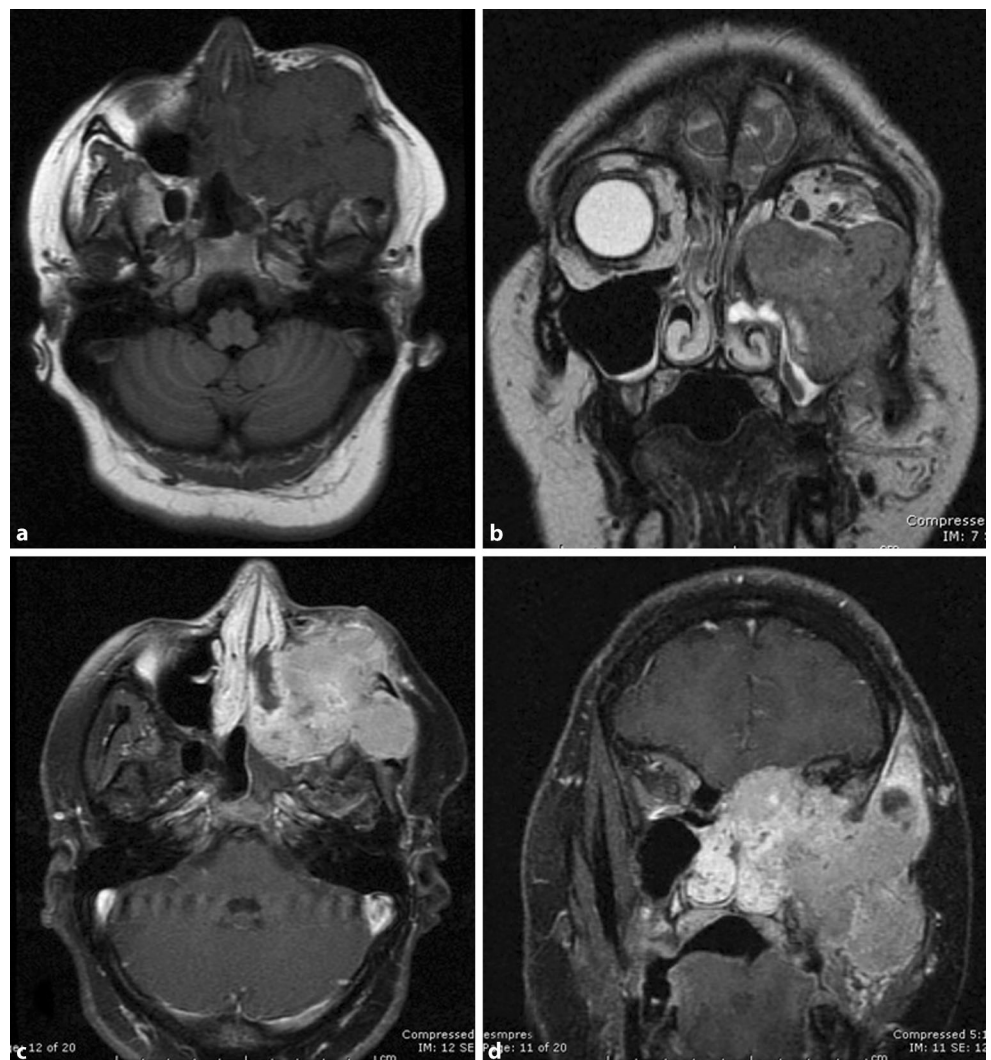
Magnetic resonance imaging (MRI). Large solid expansive left orbito-maxillofacial process with intracranial invasion and moderate enhancement following intravenous injection of paramagnetic contrast medium. a T1 axial view. b T2 coronal view. c T1 fat-saturated gadolinium axial view. d T1 fat-saturated gadolinium coronal view
